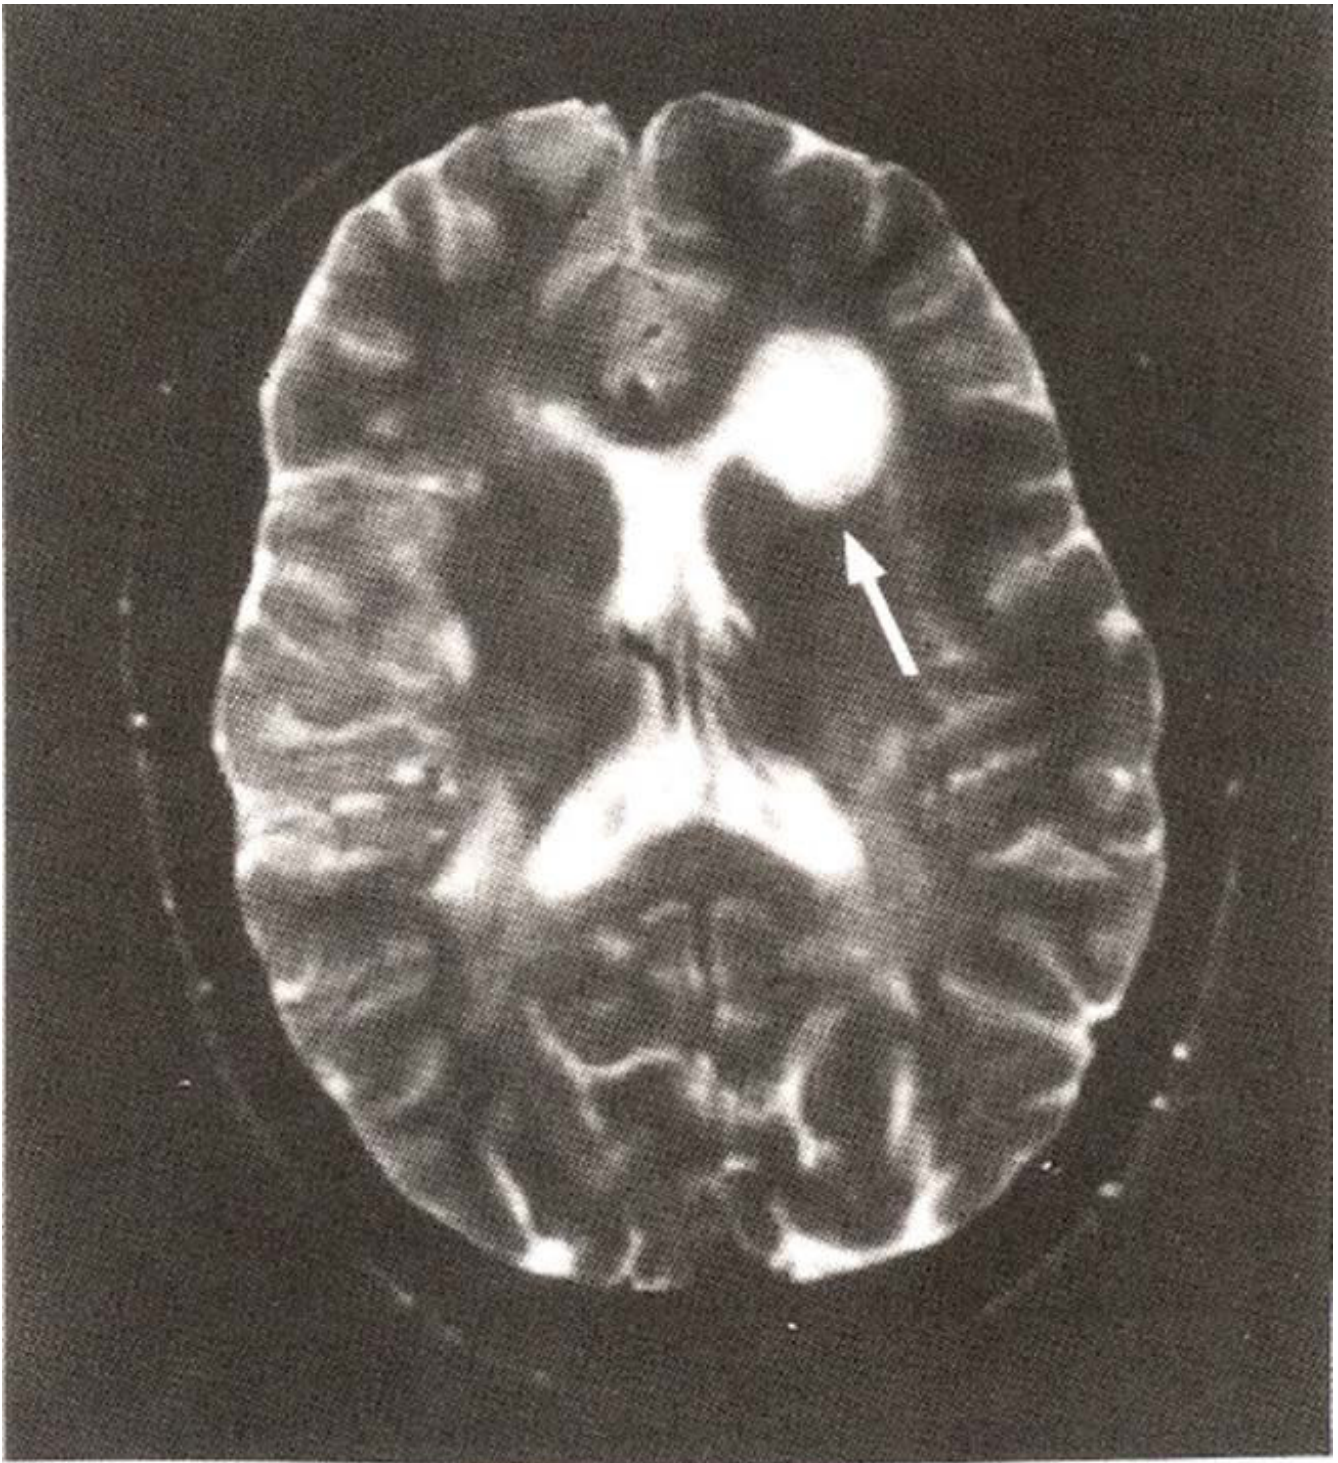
Brain MRI showing a well defined area of high signal intensity (arrow) demonstrating a ring-like enhancement (arrow).
